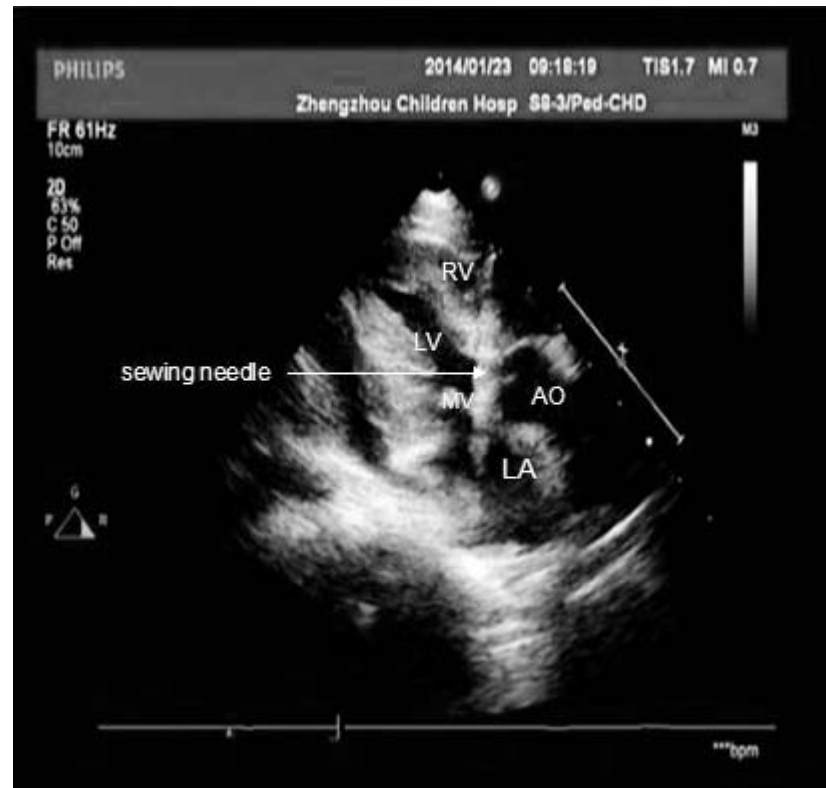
Transthoracic echocardiography revealed a linear metallic foreign body within the heart. RV, right ventricle; LV, left ventricle; LA, left atrium; AO, aorta; MV, mitral valve.
